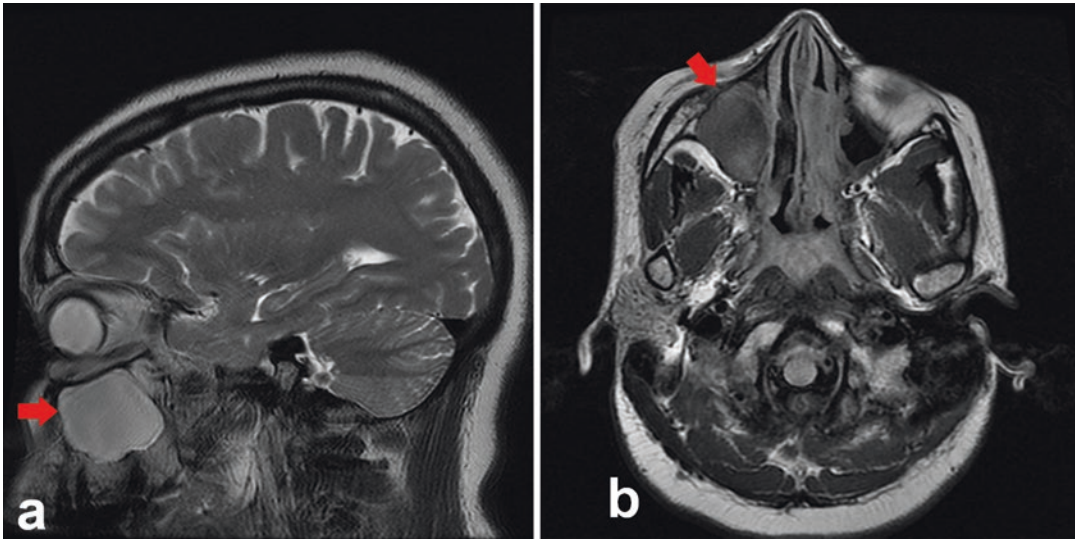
MRI imaging demonstrating right ethmoid opacification (arrow). (a) Sagittal view. (b) Axial plane
